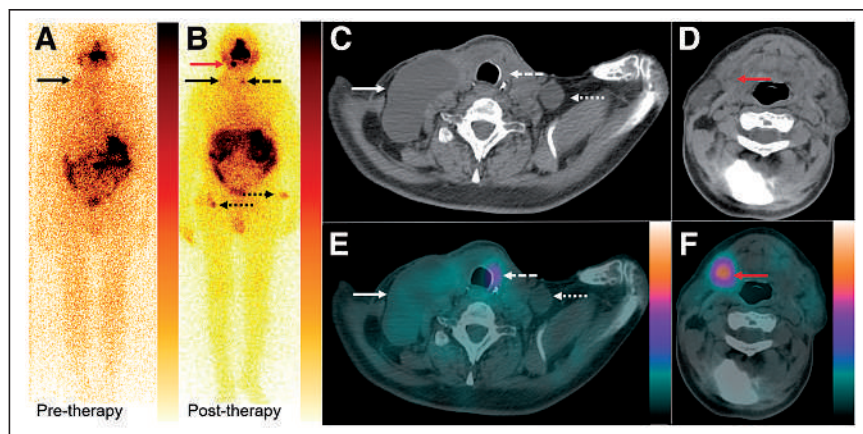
(A and B) Whole-body diagnostic (A) and posttherapy planar (B) anterior scans showing faint uptake in right supraclavicular region (solid black arrows) and increased uptake at midline of neck (dashed black arrow), in right submandibular region (red arrow), and bilaterally in thigh regions (dotted black arrows). (C–F) CT and SPECT/CT of the head and neck region are shown. Posttherapy CT (C [CT of the neck region] and D [CT of the head region]) and SPECT/CT (E [SPECT/CT of the neck region] and F [SPECT/CT of the head region]) images showing faint tracer avidity in right supraclavicular hypodense collection (solid white arrows), non-tracer-avid left supraclavicular hypodense collection (dotted white arrows), tracer-avid thyroid bed remnant (dashed white arrows), and tracer-avid right level IB cervical lymph node (red arrows).
